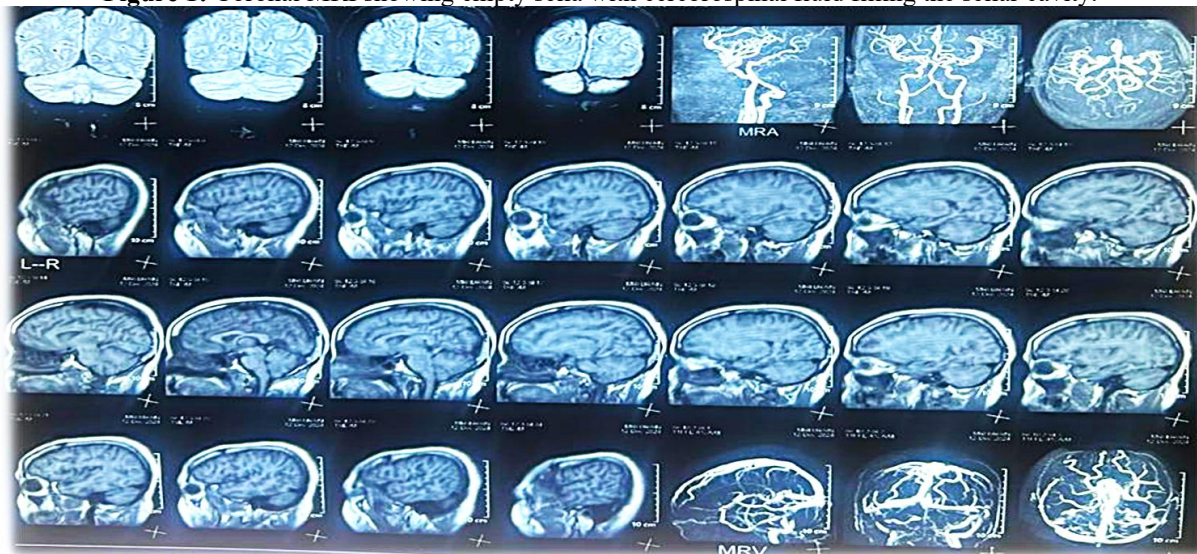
Sagittal T1-weighted MRI showing flattened pituitary tissue against the sellar floor.
